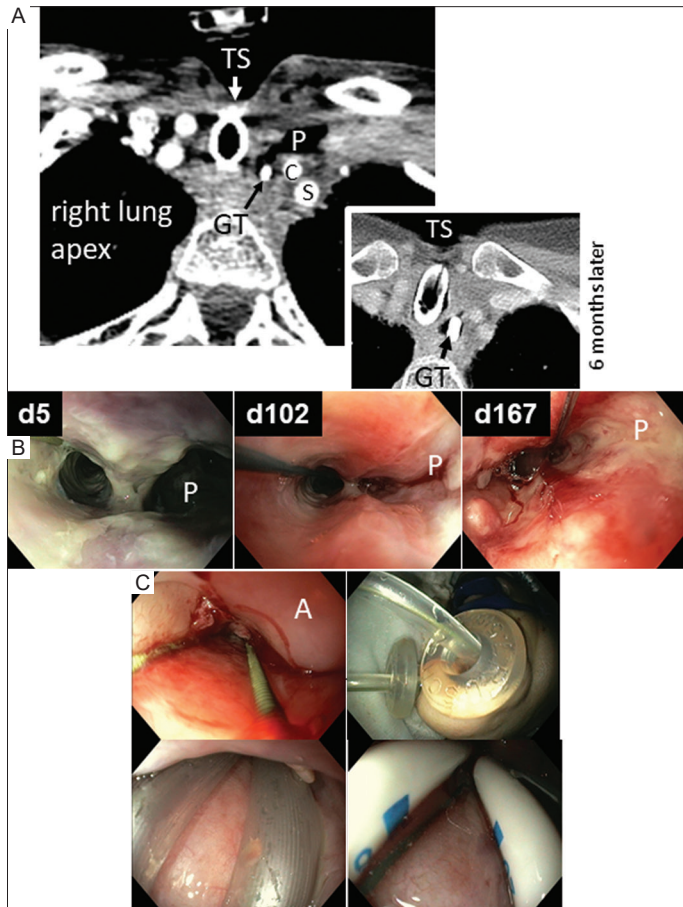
Perioperative complications. (A) Axial computed tomography plane of the upper thorax aperture demonstrates the soft tissue pocket (P) at the plane of the tracheostomy (TS) adjacent to the common carotid artery (C), left subclavian artery (S) and left lung. The gastric tube (GT) was placed as a placeholder in the esophageal lumen. The inset is an image showing the condition after tissue pocket healing 5 months later. (B) The time-consuming healing of the tissue pocket (P) delayed the progress of bougienages by approximately 100 days. (C) To keep the dilated esophageal entrance next to the arytenoid cartilage (A) open until subsequent bougienage, two guidewires for two gastric tubes were inserted (upper left). Wire-guided and simultaneous insertion of the two gastric tubes had to be assisted by Wendl tubes, one in each nostril (upper right), which splinted the pharynx (lower left) and enabled the simultaneous insertion of two gastric tubes (lower right).
